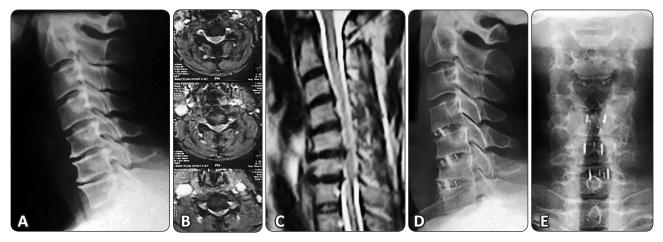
45-year-old man suffered from multi level cervical discs C4/5, C5/6, C6/7. (A,B,C) Preoperative lateral X-ray and MRI demonstrated significant compression of the spinal cord and flattening of the sagittal plane. The patient underwent multilevel anterior cervical discectomies C4-C7 and cages. (D) Postoperative lateral X-ray showing satisfactory discectomies and midline cage with adequate height comparable to healthy discs to avoid adjacent segment disease. The patient improved clinical on JOA from 11 to 13 and Nurick DI from 3 to 4.
